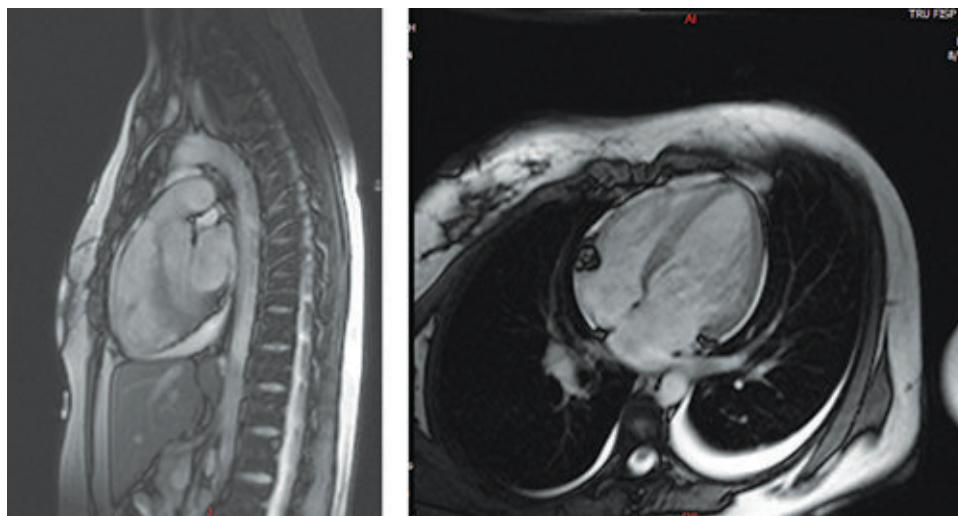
Cardiac MRI showing features of myocarditis.
